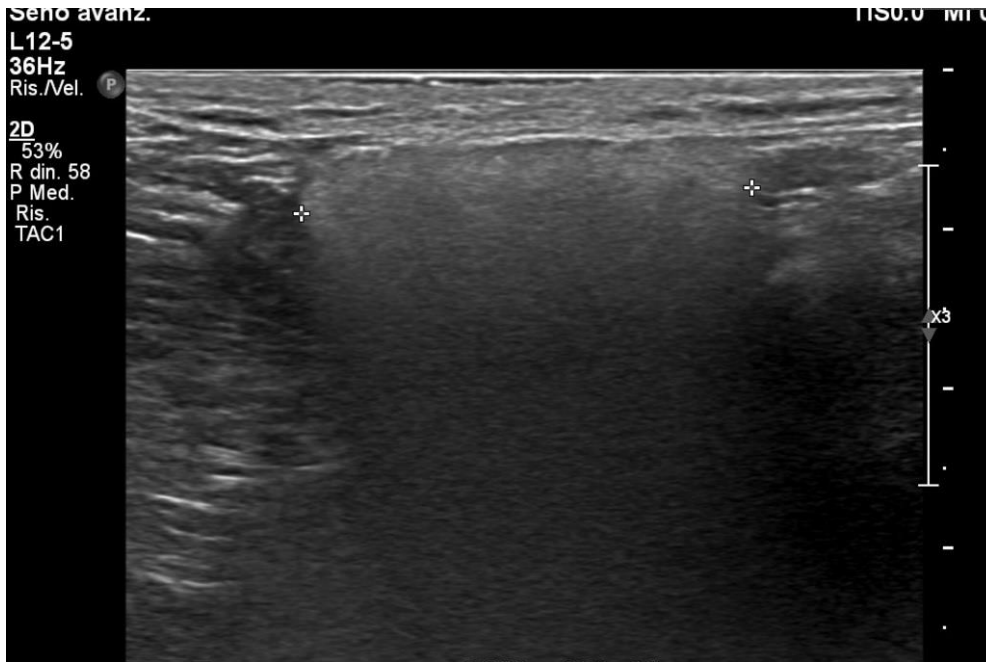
Case 1: Left axillary ultrasonography shows that the lymph node there looks like a snowfall.
